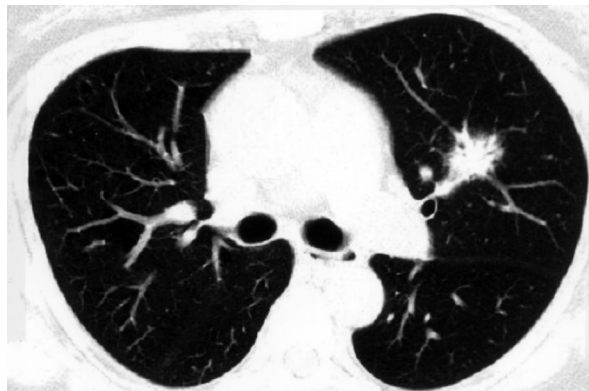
A spiculated nodule, with minimal air bronchogram, was located centrally at the left upper lobe of the lung on chest CT.
